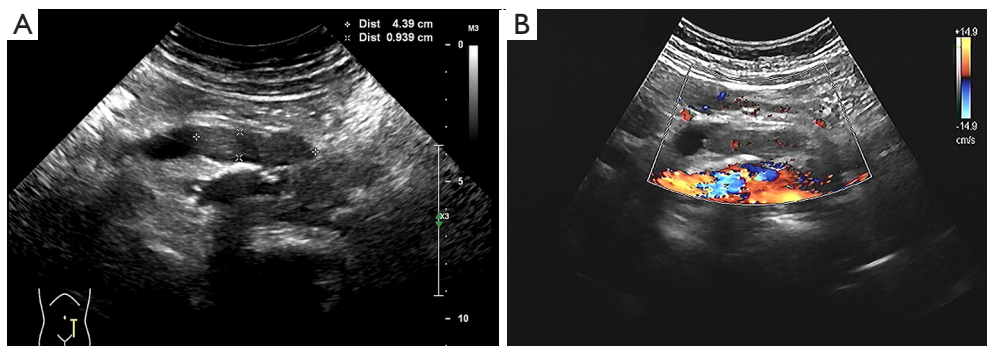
Ultrasound scanning of ureteral DSRCT (transverse view). (A) A hypoechoic mass measuring 3.92 cm × 1.47 cm in size was observed 5.0 cm from the left renal hilum-ureteral junction (within the ureter). (B) CDFI showed a class I flow signal within the lesion. DSRCT, desmoplastic small round cell tumor; CDFI, color Doppler flow imaging.
